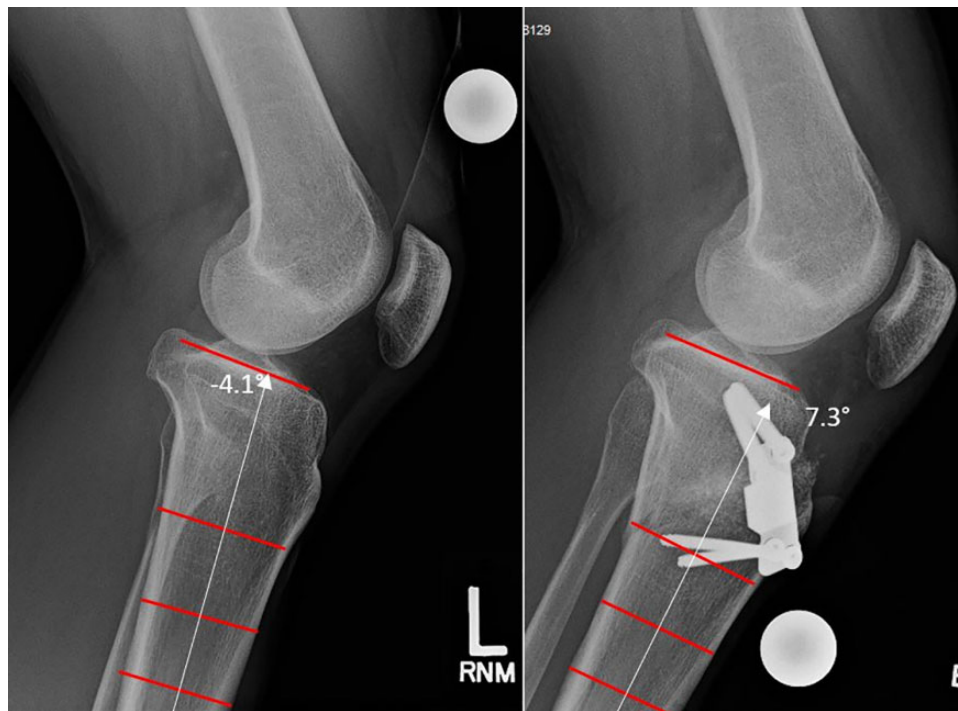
Example of lateral radiographic images demonstrating the correction of symptomatic genu recurvatum using an anterior opening-wedge proximal tibial osteotomy from our practice. The posterior tibial slope (PTS) was corrected to a more posterior position; the tibial slope of the preoperative image (left) was -4.1° (tibial slope in the anterior direction), and the PTS after correction (right) was 7.3° .
